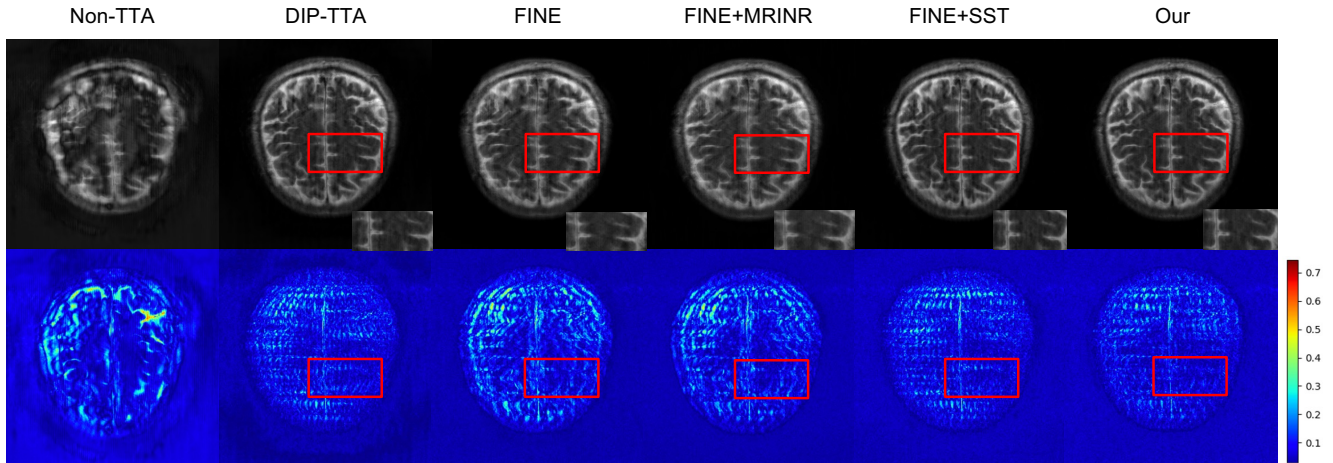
Comparison of different frameworks in UNet under anatomy shift (Knee to Brain) using the FINE method. The first row shows reconstructed MRI images, while the second row presents residual maps between reconstructions and full-sampled MRI. The proposed method (far right) achieves the lowest residuals, indicating improved reconstruction accuracy
